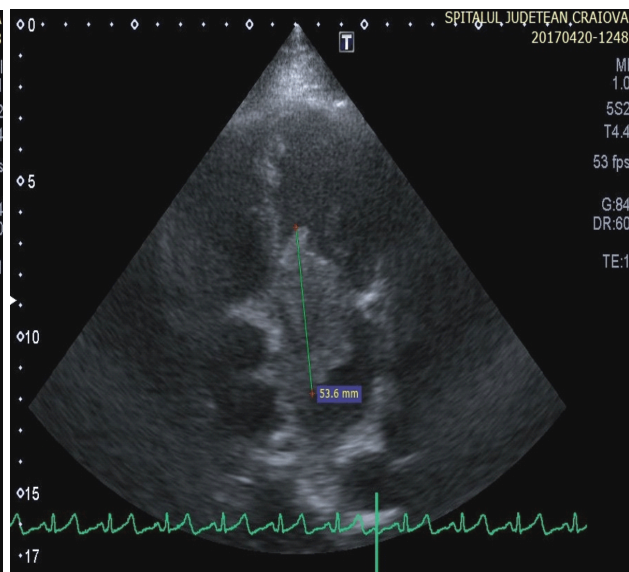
Transthoracic echocardiography (TTE), apical four-chamber view: large atrial myxoma located in the left atrium and inserted on the interatrial septum.
